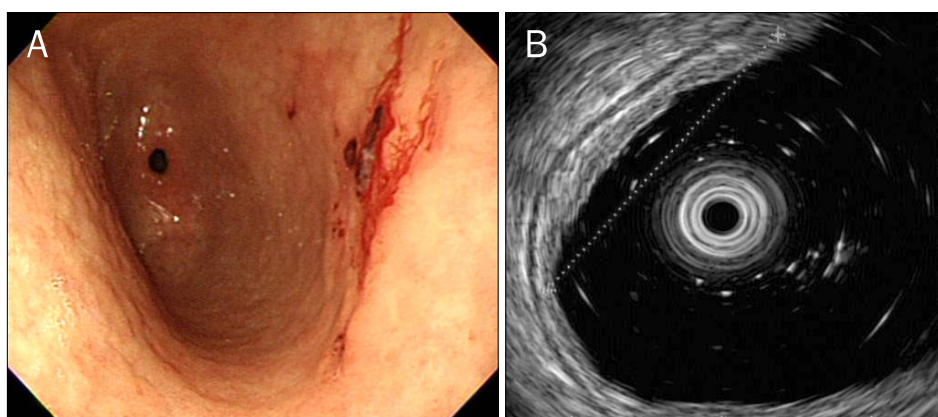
(A) Initial gastroscopy. An irregularly elevated lesion, which bled easily when touched, is noted at the posterior wall of the antrum. (B) Endoscopic ultrasound. The lesion measured 3.0 cm at the long axis and is limited to the mucosal layer.
